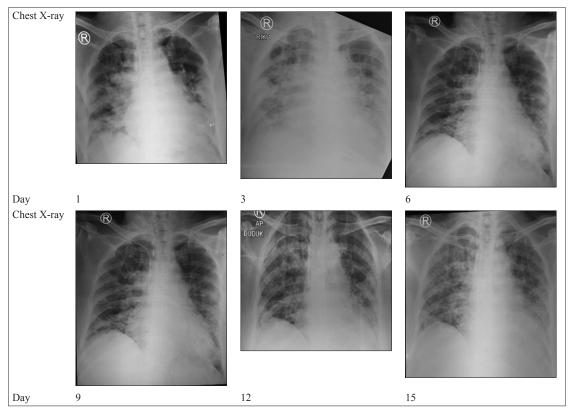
Serial chest X-ray
